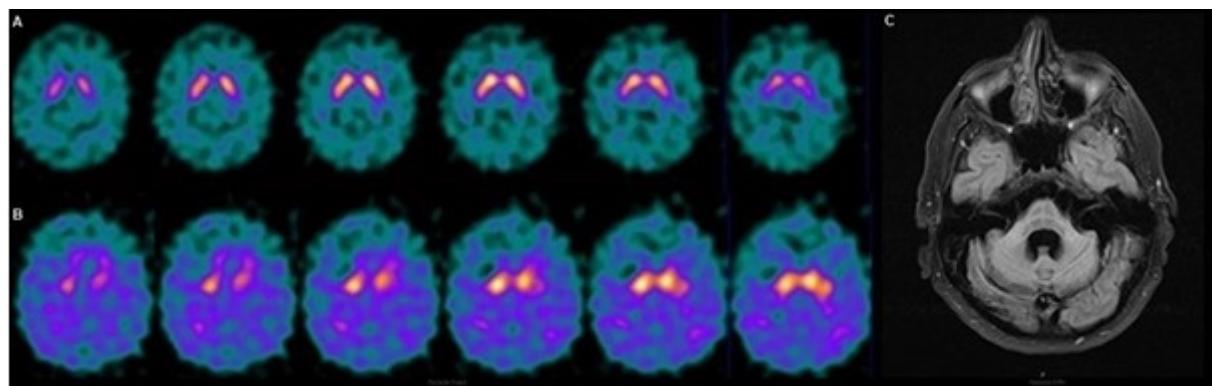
Follow-up of patient with MSA-C. A 62-year-old woman with MSA-C with dysautonomic, parkinsonian, and cerebellar symptoms, unresponsive to levodopa treatment. The evolutionary SPECT allowed the detection of bilateral striatal disease. (A) Anodyne basal SPECT. (B) Evolutionary SPECT at 12 months with noticeable bilateral striatal dysfunction. (C) MRI showed the characteristic “hot cross bun” sign in the cerebellum. The SPECT images are at 5 cm and the MRI image is at 10 cm.
